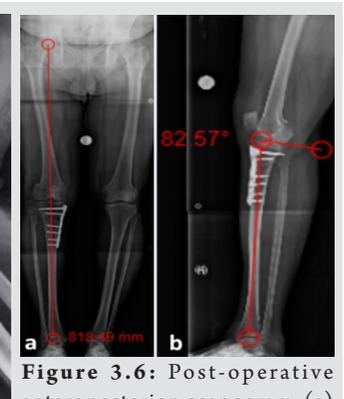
Post-operative radiograph of the patient showing the fixation in-situ. The posterior tibial slope was not altered (b).
